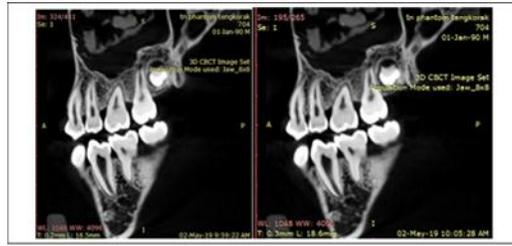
CBCT images of skull scan after Image-J filtering
